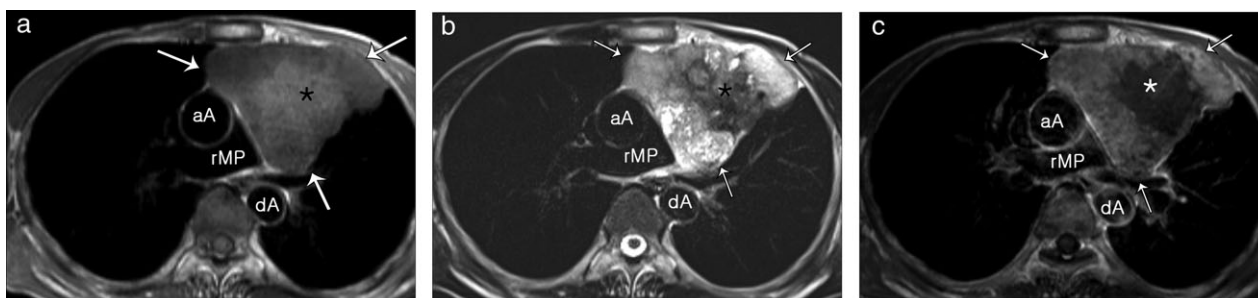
Double inversion-recovery (IR) (a) T1 weighted, (b) T2-weighted, and (c) gadolinium-enhanced T1 weighted chest magnetic resonance imaging at one month follow-up. A huge, prominent heterogeneous anterior mediastinal mass (arrows, a–c) contains a relatively large hemorrhagic and necrotic portion, which shows subtle high signal intensity on T1 weighted image (asterisk, a), a heterogeneous mixed area of strong high and dark signal intensities on T2 weighted imaging (asterisk, b), and low signal intensity without contrast enhancement on contrast-enhanced T1 weighted image (asterisk, c). (c) The remaining portion of the mass shows heterogeneous enhancement, which is suggestive of malignant potential. aA, ascending thoracic aorta; dA, descending thoracic aorta; rMP, right main pulmonary artery.
